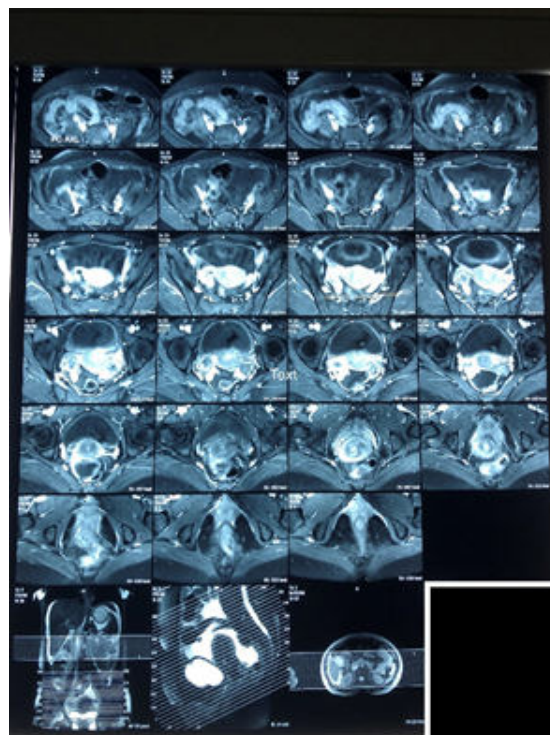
MRI contrast of the Abdomen and Pelvis showing moderate ascites as well as thick parietal peritoneum, mesenteric edema.
